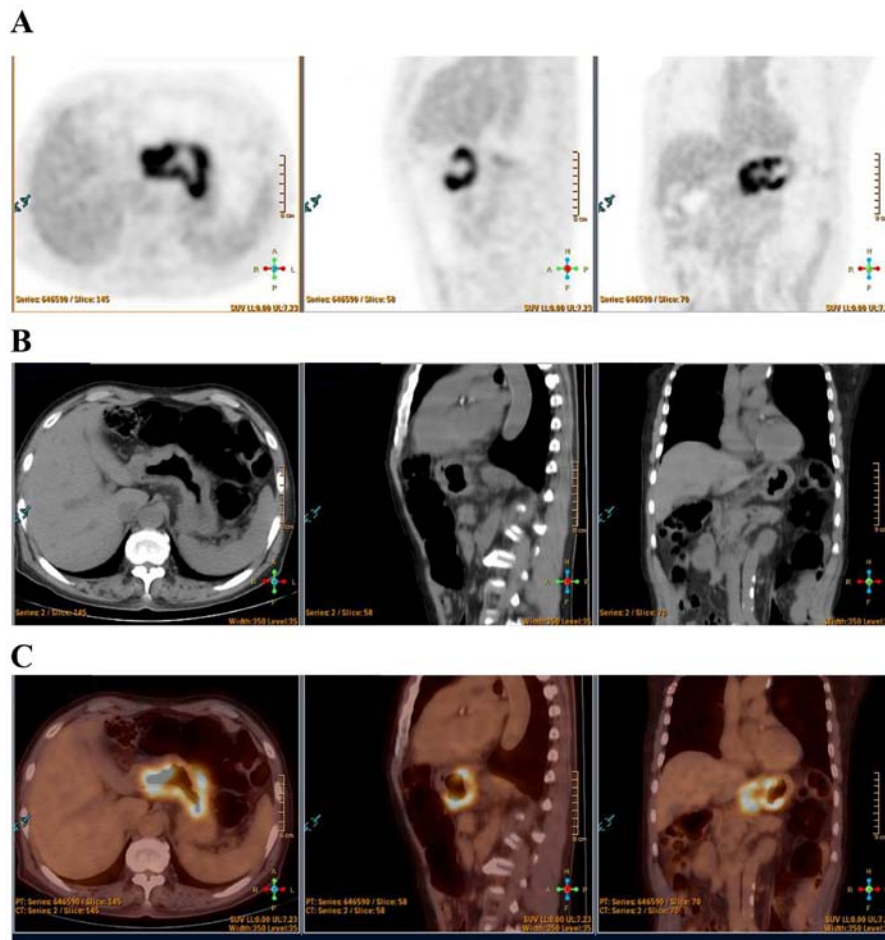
Representative images of PET-CT for gastric adenocarcinoma patients. Transaxial images of (A) FDG-PET, (B) diagnostic CT and (C) fusion of PET and CT images.
